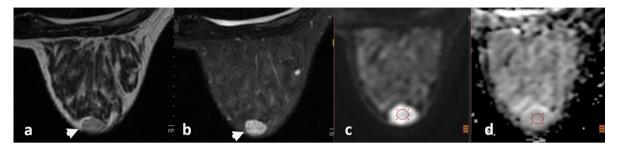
A 27-year-old female presenting with enlarging periareolar mass. (a) T2-weighted axial and (b) Fat-saturated T2-weighted axial images delineate a well-circumscribed oval retroareolar lesion (arrowheads). (c) Diffusion-weighted imaging and (d) corresponding Apparent Diffusion Coefficient maps show restricted water diffusion within the lesion. ADC measurements are performed using a free-hand elliptical ROI (ovals).
